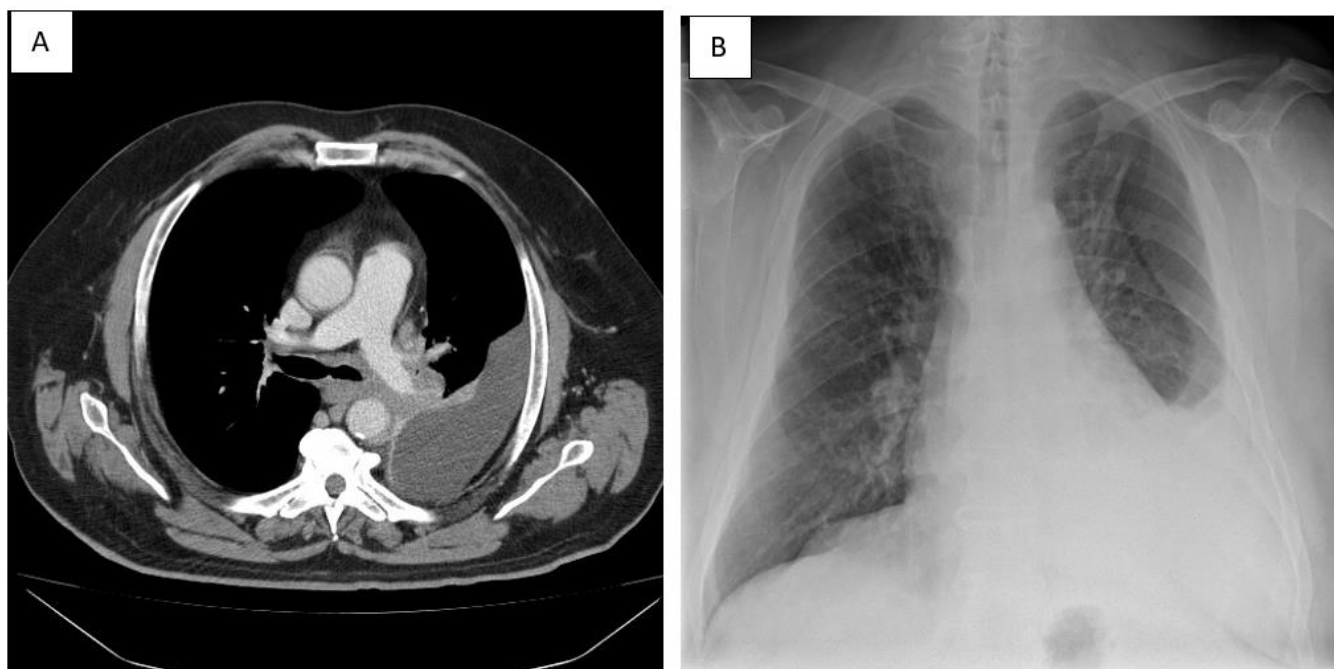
A) Post-treatment chest radiography after R-CHOP showing partial re-expansion of the left lung, with marked reduction of the previous opacification and reappearance of the left cardiac and diaphragmatic contours, as well as regression of the rightward mediastinal shift with recentring of mediastinal structures; B) Post-treatment chest computed tomography demonstrating reduction of the mediastinal mass to 8 × 3.8 cm, along with decreased pleural effusion.
